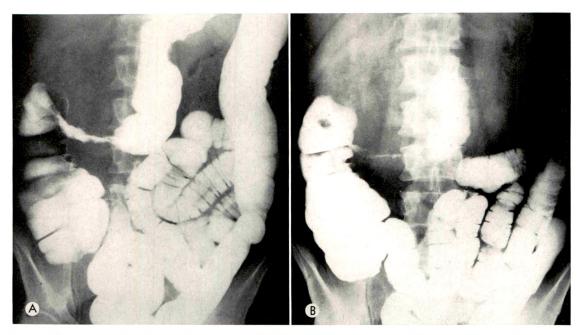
Case IV. A. H., white male, 48 years old. Weight loss, anorexia and frequent vomiting for I year. Sudden onset of severe epigastric and right upper quadrant pain, nausea and vomiting; fever, leukocytosis and albuminuria. Subtotal gastrectomy for duodenal ulcer 3 years previously. Final diagnosis: hemorrhagic pancreatitis (huge mass of hemorrhage and pancreatic fat necrosis on the right side). (A) Sharply narrowed transverse colon segment near hepatic flexure  $2\frac{3}{4}$  inches in length. Shaggy margins, tapering ends. Apparent mucosal destruction. (B) Postevacuation roentgenogram. Although this is a benign lesion there is retention in ascending colon. The edematous infiltration is sufficient to cause obstruction.
